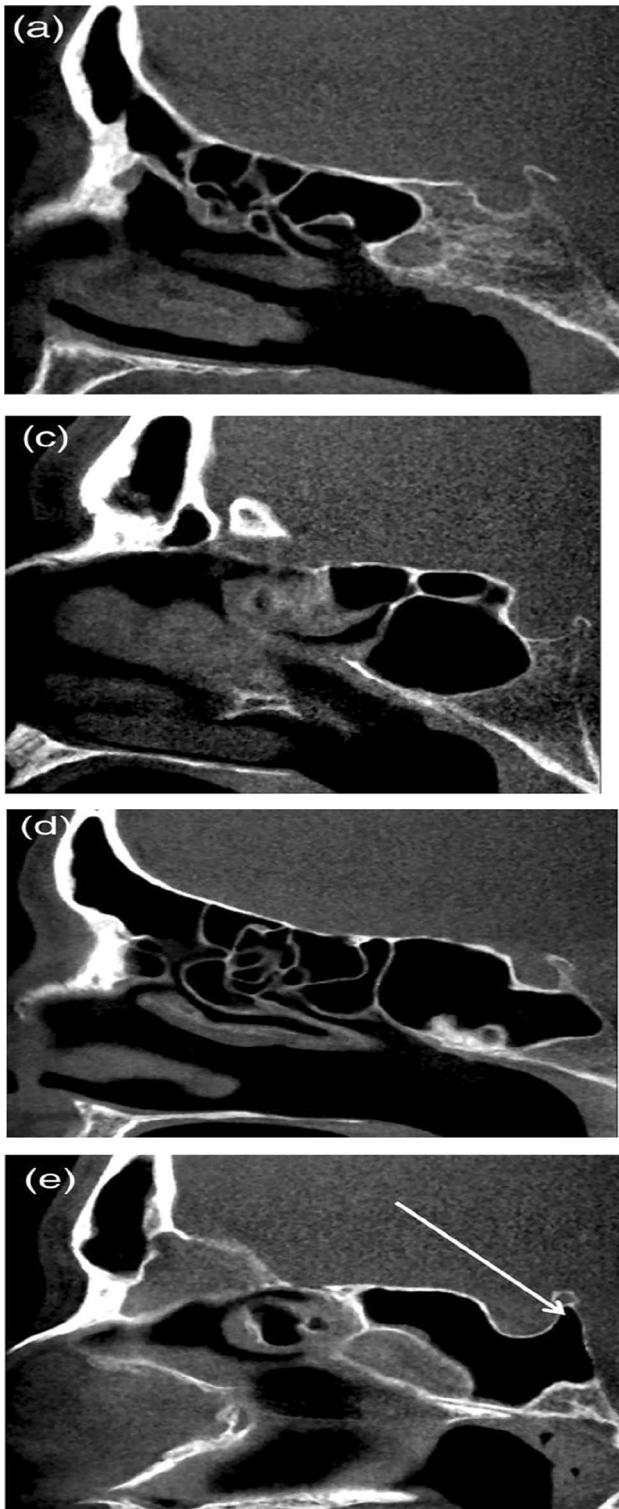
CT scan showing different types of sphenoid sinus pneumatization patterns; a Conchal type; c Pre-cellar; d Sellar; e Post cellar
